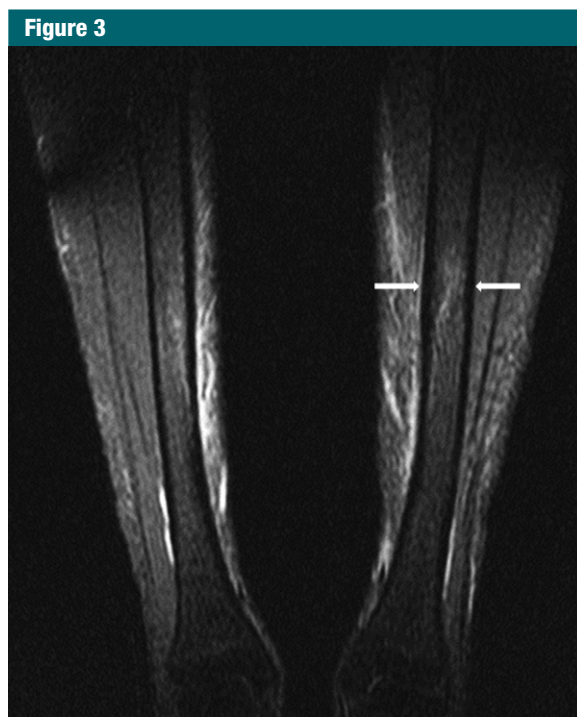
Coronal STIR MR image (2420/34; inversion time msec, 130; field of view, 250 mm) shows grade II stress reaction. There is a patchy area of bone marrow edema in the left tibia (arrows) that is amorphous and cloudlike.
